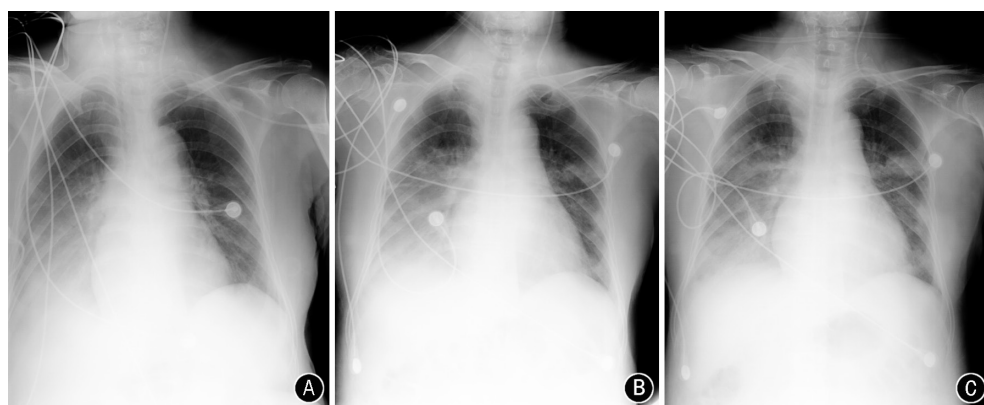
Three images of an 81-year-old female were obtained on days one (A), two (B), and three (C) after admission. Chest X-ray shows bilateral lung lesions that progressed extensively during treatment.
